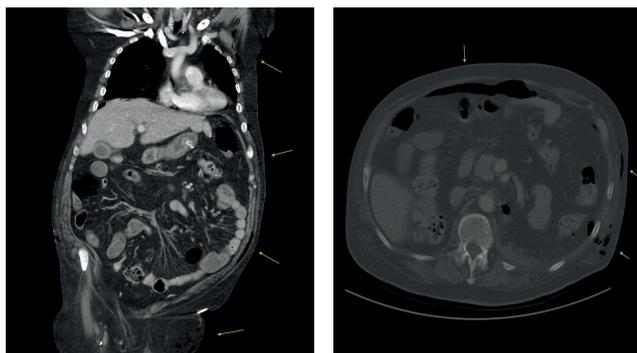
Coronal (left) and axial view of the first CT abdomen. Subcutaneous and free intra-abdominal air is indicated by green arrows.
